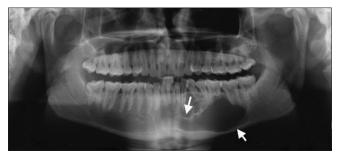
Orthopantomogram depicting unicystic radiolucency extending from 36 to 44. Arrow mark indicating the extent of the radiolucency
